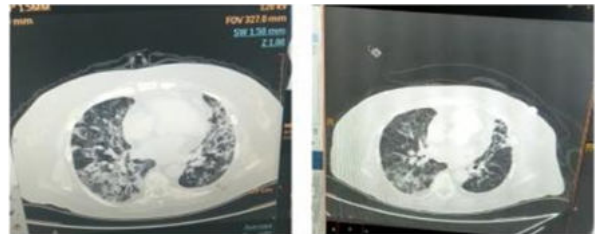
Earlier the HRCT showed focal patchy area of ground glass opacities with predominant thick intervening areas of intra lobular septal thickening CTSI 17 which later improved to CTSI of 11
